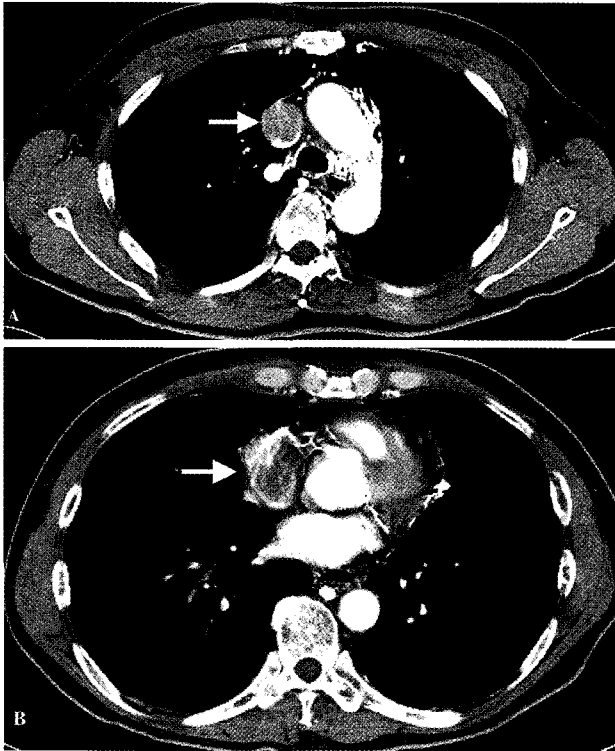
(A) Axial image of CT scan in arterial phase demonstrated tumor thrombus (arrow) expanding the superior venous cava. (B) In right atrium, there was also tumor thrombus (arrow) which near totally obliterating chamber.
